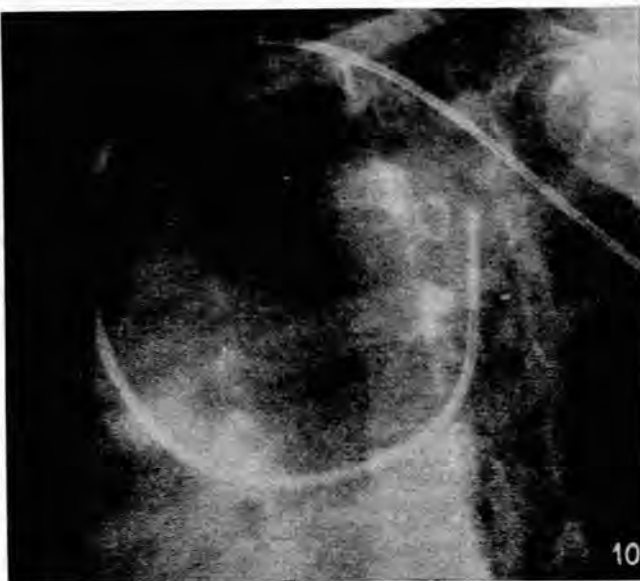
Left anterior-oblique radiograph showing cardiac catheter in a pulmonary vein, *via* the atrial septal defect and left atrium.
